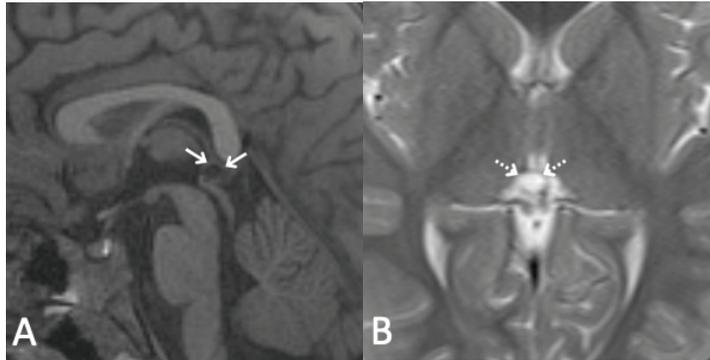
On MRI, a cystic lesion consistent with true pineal cyst (A) which appears hypointense in T1-weighted sagittal sequences and (B) hyperintense in T2-weighted axial sequences.
